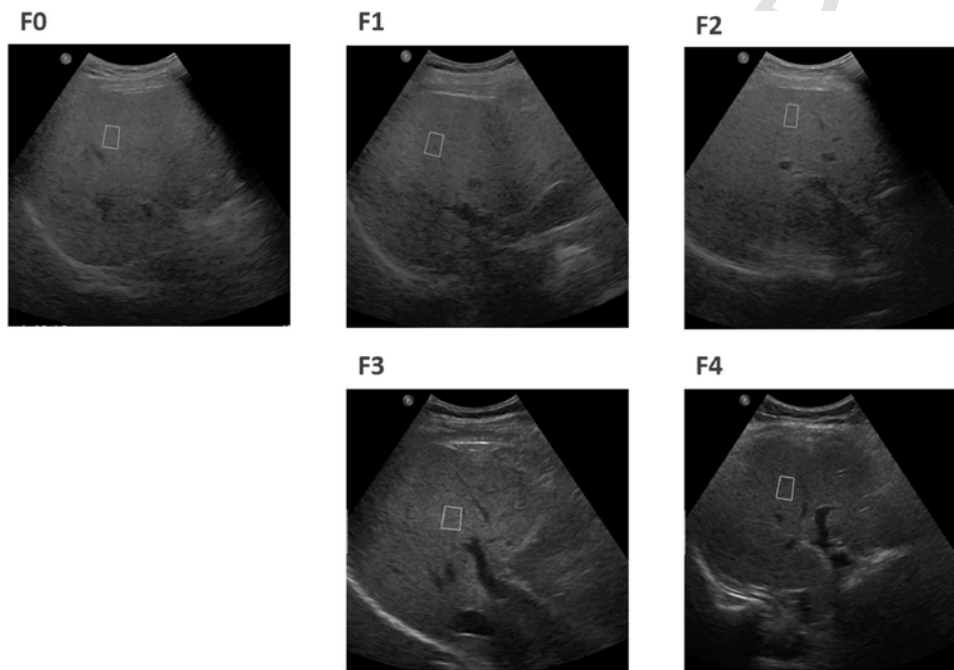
Sample ultrasound images belonging to different liver fibrosis stages. F0: no fibrosis, F1: minimal fibrosis, F2: moderate or clinically significant fibrosis, F3: severe fibrosis, F4: cirrhosis.
